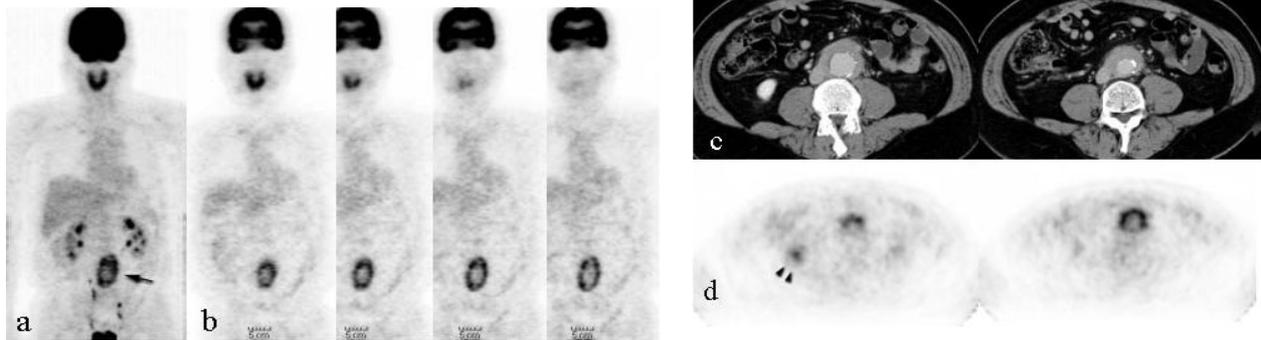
a, b: FDG-PET shows intense FDG uptake surrounding the abdominal aorta. c, d: CT images show a soft tissue density area around the abdominal aorta and expanding to the inferior vena cava. Axial view of FDG-PET demonstrates intense FDG accumulation corresponding to soft tissue density. Normal physiologic radioactivity is also seen in the right kidney (*arrowhead*). (c, contrast-enhanced CT; d, FDG-PET axial views corresponding to the CT images.)
